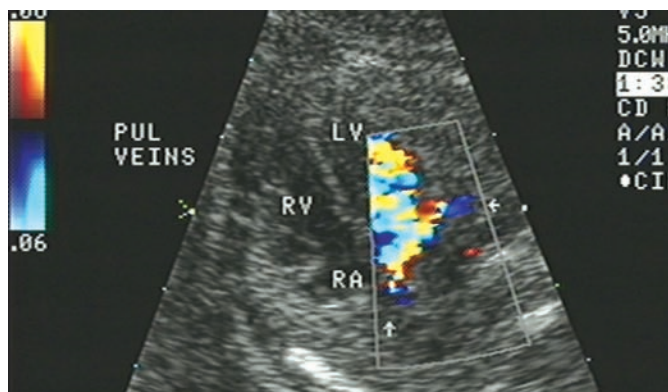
Color Doppler of normal pulmonary venous connections.
